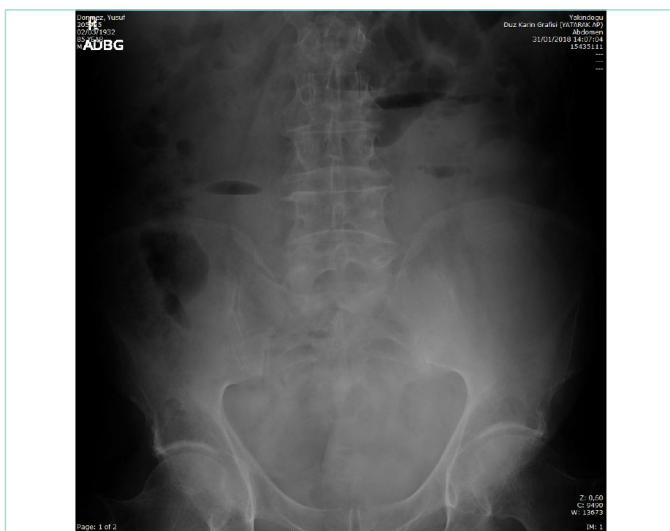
Air fluid levels and dilated intestinal segments on plain abdominal X-ray.
